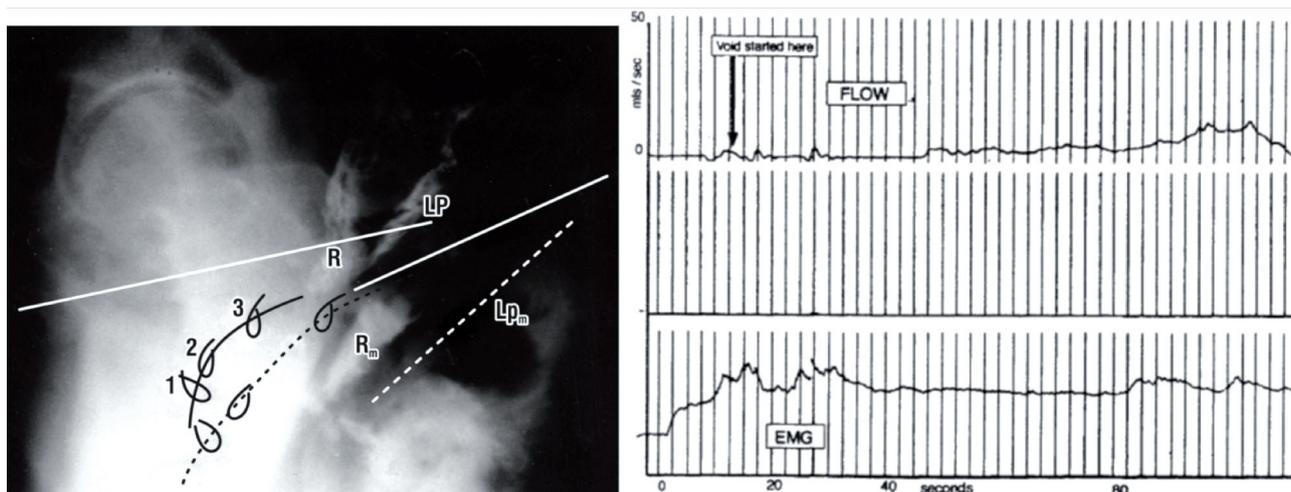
Micturition x-ray superimposed on resting xray (left side), patient sitting. Vascular clips have been applied to the midurethra '1'. Bladder neck '2' and bladder base '3'. Radio-opaque dye has been injected into the levator plate 'LP', which has been angulated downwards during micturition, as has the rectum 'R', which has 10 ml of barium paste. Broken lines indicate position of organs during micturition. Subscript 'm' indicates the position of rectum 'R' and levator plate 'LP' during micturition. Surface EMG (right side) Surface EMG cylinder placed in the posterior fornix of the vagina simultaneous with uroflowmetry. EMG shows that muscle contraction preceded urine flow.
